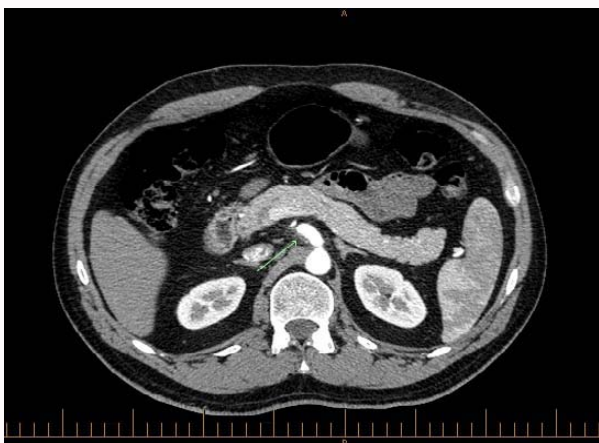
Celiac Artery Dissection identified on CT abdomen (Trauma protocol).
